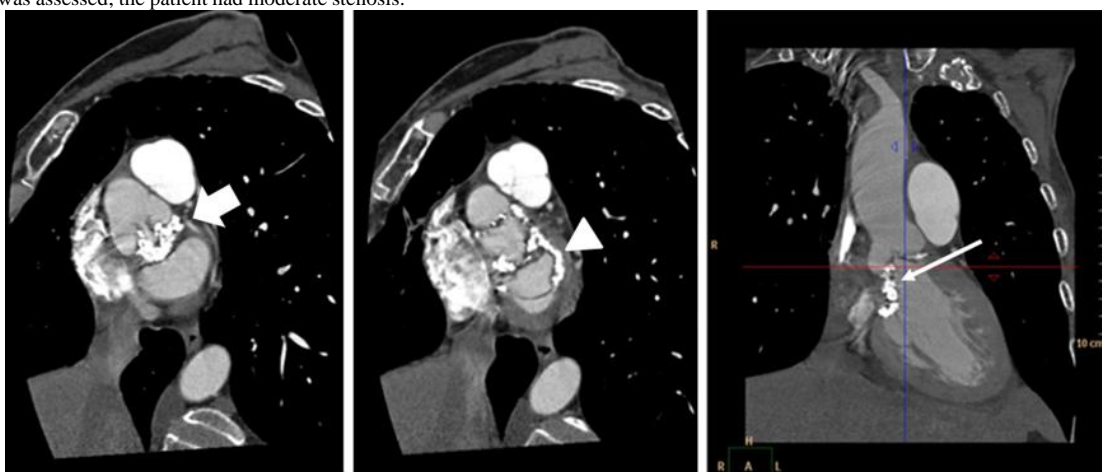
Multislice Computed tomographic imaging demonstrating extended calcification that affects the aortic and mitral valve with extension to the LVOT (thick arrow), the mitral ring (arrow head) and the mitro-aortic curtain (thin arrow).
